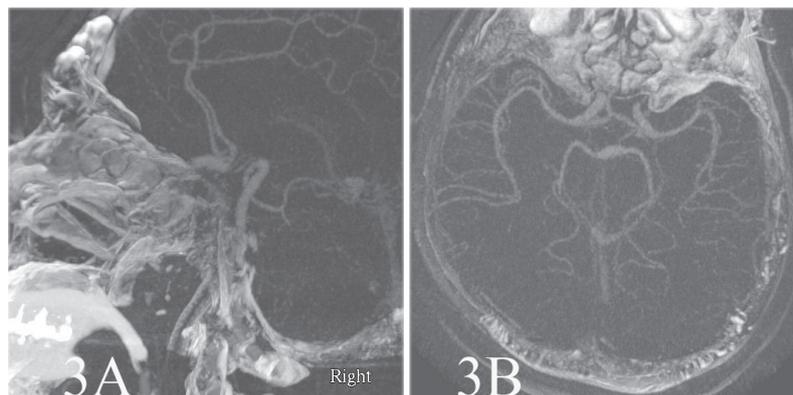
CT examination before endovascular neurovascular salvage. CT angiography reveals stent placement at cervical to proximal petrous segment of right ICA with long segmental thrombus and total occlusion of right ICA, from its origin to cavernous segment (3A); The circle of Willis is patent (3B).
